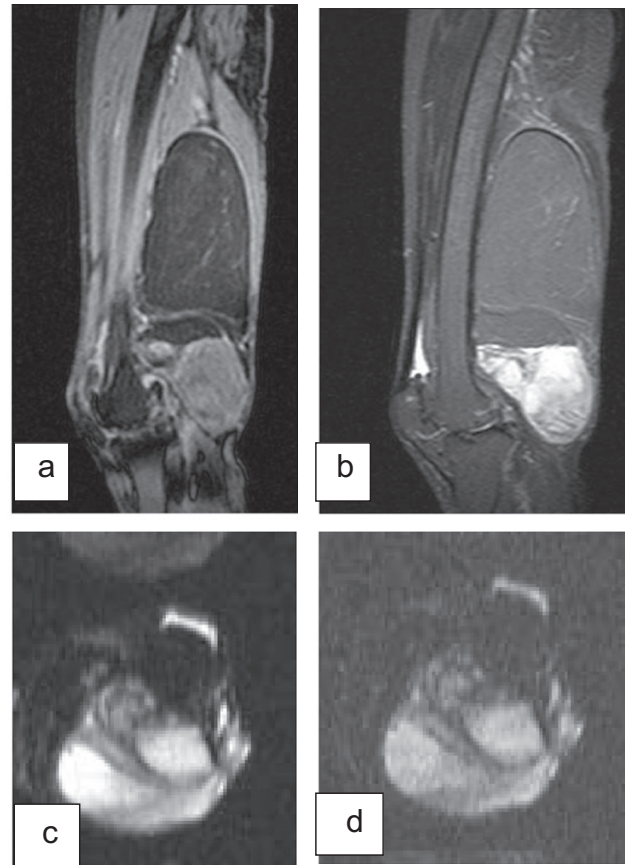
Liposarcoma of the thigh. The soft tissue component appears of high signal in sagittal fat suppression sequence (a) and intensely enhancing in sagittal T1 fat suppression (b) and showing restriction in DWI(c,d) and ADC . ADC Value 1.1 ± 0.13 .
